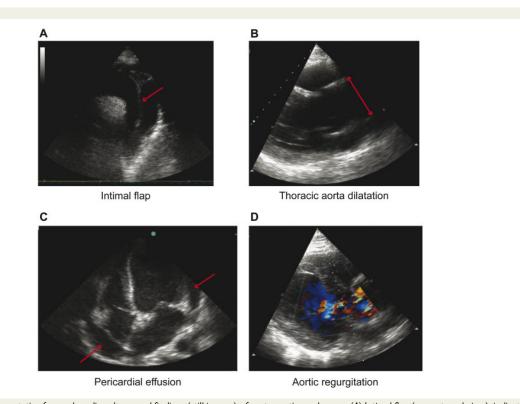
Figure I Representative focused cardiac ultrasound findings (still images) of acute aortic syndromes. (*A*) Intimal flap (suprasternal view), indicated by a red arrow. (*B*) Ascending aorta dilatation (>4 cm, left parasternal view, leading edge measurement as indicated by red arrow). (*C*) Pericardial effusion (apical view), indicated by two red arrows. (*D*) Aortic valve regurgitation (left parasternal view, colour Doppler). Still images were obtained from Supplementary material online, Videos S1–S4.
